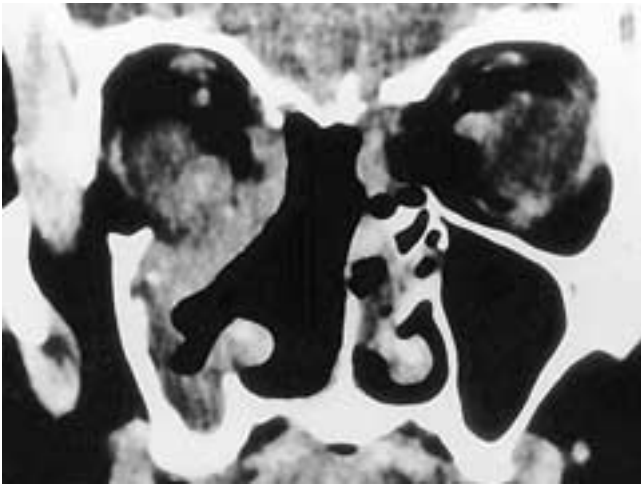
Coronal CT scan on a patient after an extended right lateral rhinotomy. The floor and medial wall of the right orbit have been removed. Although the thickened soft tissues along the orbital margin could be either scar or recurrent tumor, the smooth margin suggests that tumor is not present. The best way to evaluate this disease is to compare this scan with a previous study. Biopsy may be necessary. No tumor was present in this patient.
